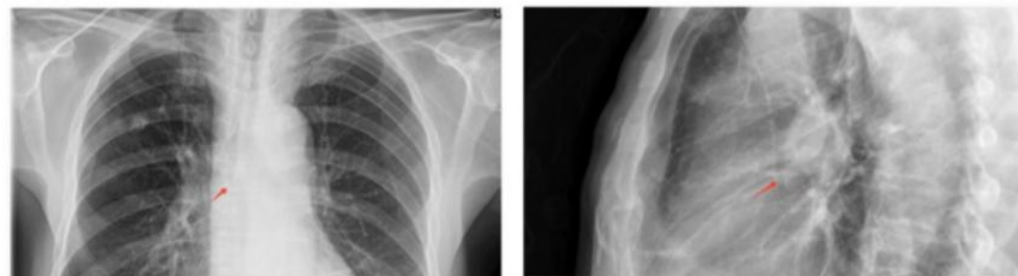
Anterior/lateral chest X-ray showing the tip of the catheter was correctly positioned in the superior vena cava (SVC)
